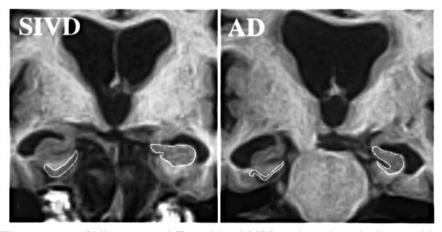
Oblique coronal T1-weighted MRI sections through the entorhinal cortex and hippocampus of a 73-year-old man with subcortical ischemic vascular dementia (left) and a 68-year-old man with Alzheimer's disease (right). The tracings indicate the boundaries of the entorhinal cortex (left) and hippocampus (right). Despite comparable levels of cognitive impairment, the AD patient has a markedly smaller entorhinal cortex and a smaller hippocampus than the SIVD patient
